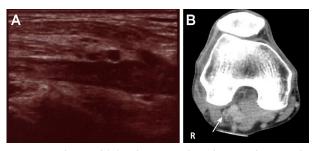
Ultrasound (A) and contrast-enhanced computed tomography (B) images of the lower extremities reveal the presence of thrombi (arrow) in the right popliteal vein 2 weeks before hospitalization. Abbreviation: R, right.
